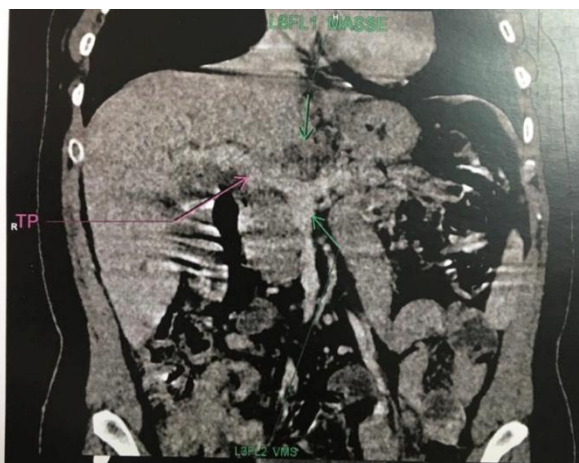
Coronal section of CT scan of abdomen showing a mass in the pancreatic head
